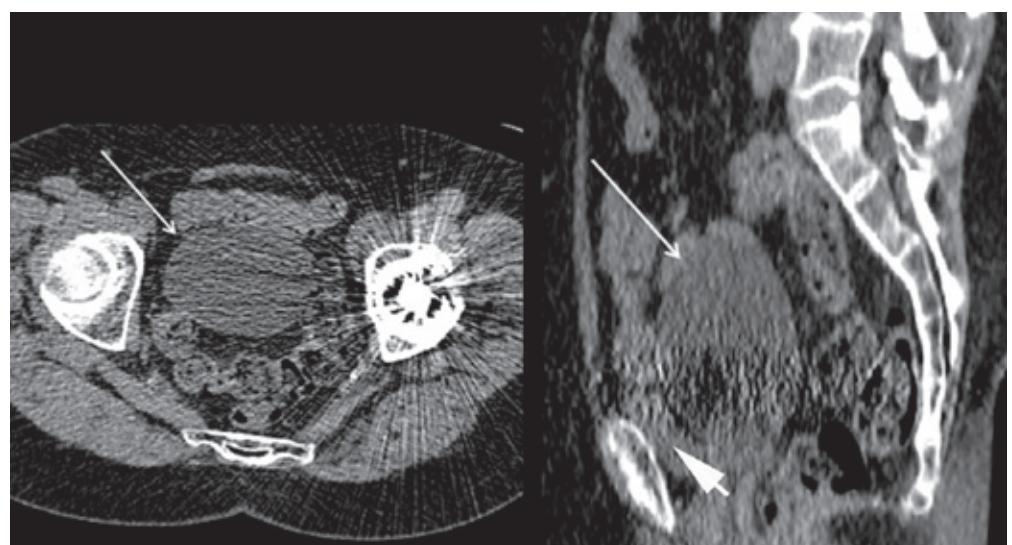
Axial and sagittal CT images from the patient in Case 1 demonstrating the ovarian cyst (thin arrow) and the collapsed urinary bladder (thick arrow).
